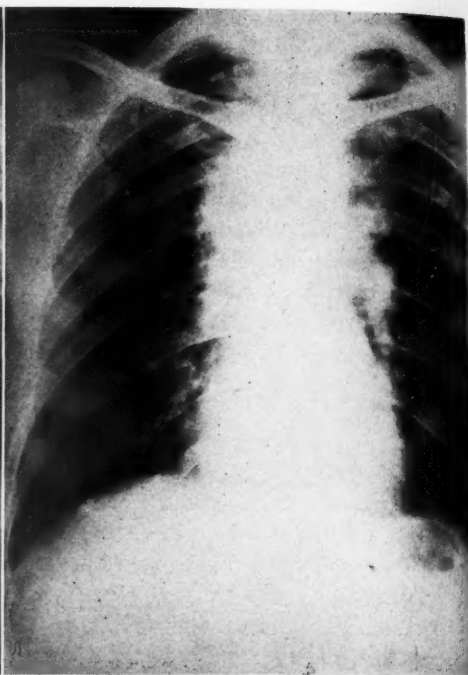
Same case, showing regression of tumor after X-ray therapy (1929).
